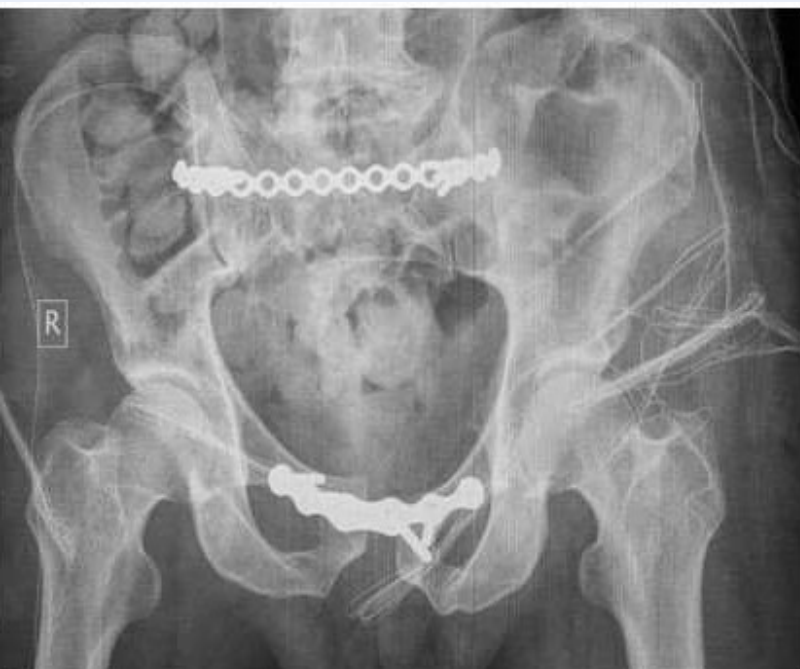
Case 3. Left: Postop x-ray, anteroposterior view demonstrates inadequate reduction of the right hemipelvis.
